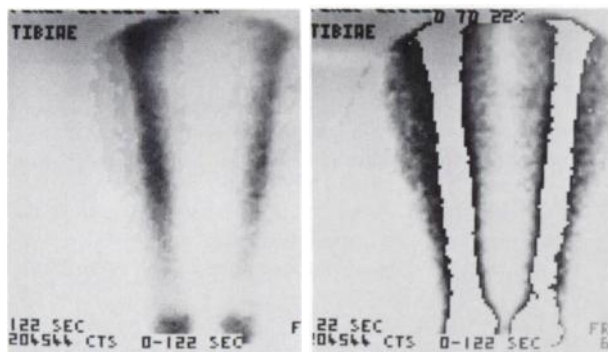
Four-hour bone scintigram (Tc-99m HEDP) of tibiae before contrast enhancement (right). Same, after contrast enhancement (left).
